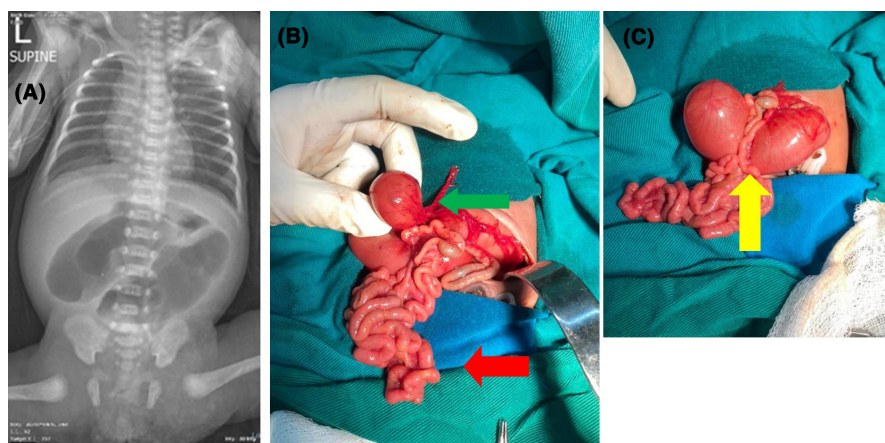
(A) Plain abdominal x-ray showing “double-bubble” sign. (B) Operative photograph showing JIA type 3b with proximal distended limb (green) and distal collapsed bowel loops (red). (C) Side-to-side anastomosis (yellow).
